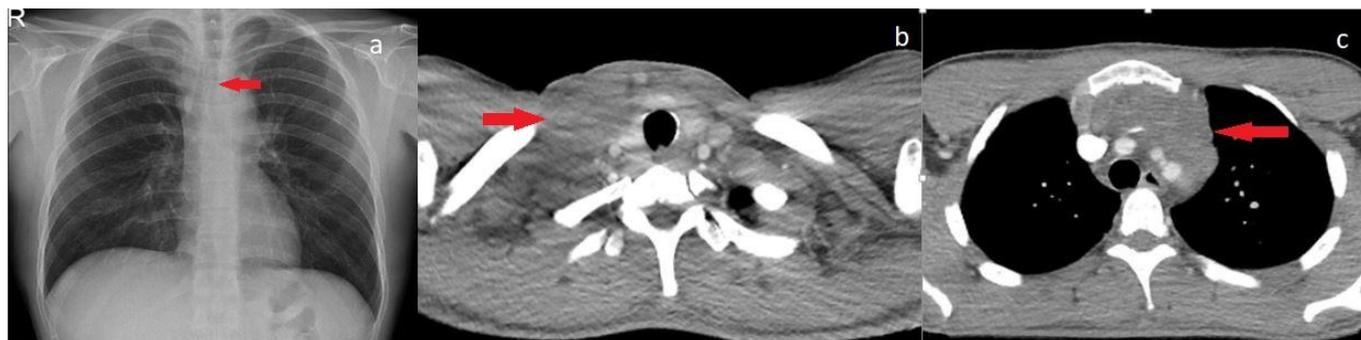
b and c: Tracheal deviation in a chest X-ray (a), enlarged lymphadenopathy in the right supraclavicular (b), prevascular mediastinal region (c)
